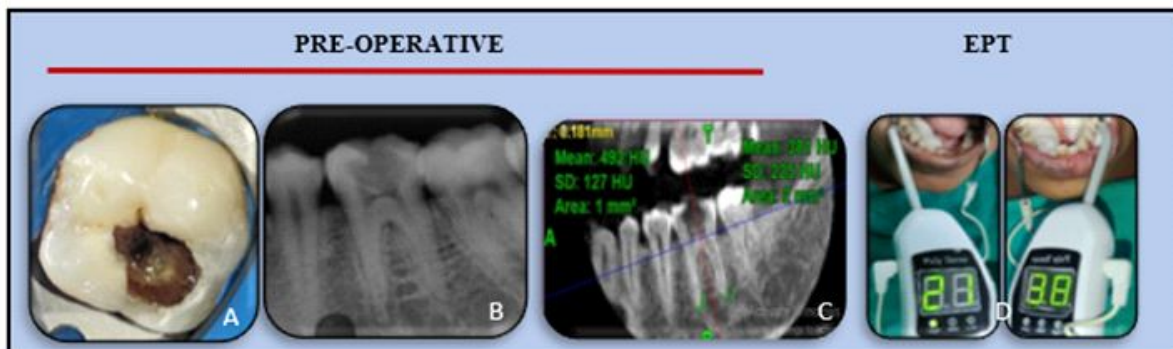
A.Pre-op clinical photograph, B.Pre-opIOPAR ,C.Pre-opCBCT, D.EPT showing positive response(Reading #46 - 21 and #36 - 38)
